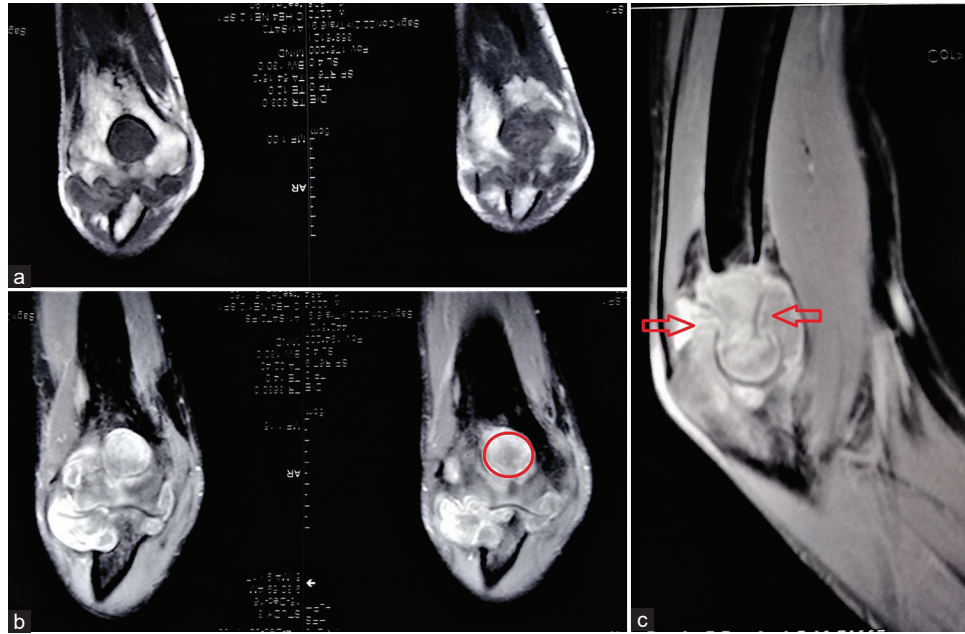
The magnetic resonance imaging coronal T1-weighted (a) and fat-suppressed (b) images show round coronoid fossa with associated synovial hypertrophy and surrounding marrow edema. The fossa has been eroded in a circular shape (denoted by the red circle) by the disease process. The sagittal image (c) shows the disease process involving the entire elbow region and engulfing the coronoid or olecranon fossa (denoted by arrows).
